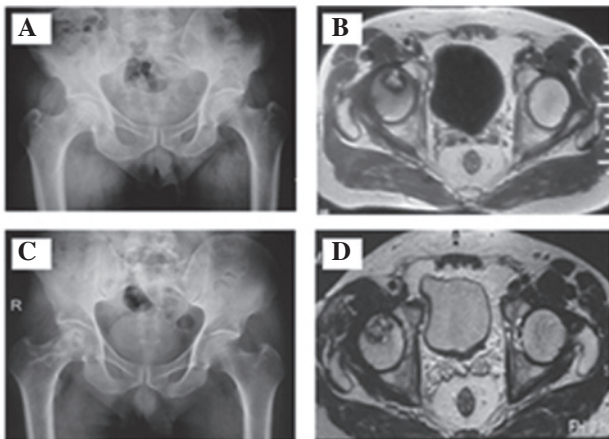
Preoperative (A) X-ray and (B) MRI and postoperative (C) X-ray and (D) MRI at the 1-year follow-up. A 49-year-old man with a 30-year history of heavy drinking (average, 50 ml/day) was admitted to hospital on April 29, 2012 with complaints of right hip pain for more than 3 months and progressive, aggravated claudication. Physical examination revealed limited motion of the right hip joint, a positive Patrick's sign, and feelings of pain under flexion, abduction and extension. The patient was diagnosed with avascular necrosis of the femoral head at ARCO stage IIB. On May 8, 2012, the patient underwent transplantation with iliac bone flaps pedicled with sartorius muscular fascia around the superficial circumflex iliac vessels. MRI, magnetic resonance imaging; ARCO, Association for Research on Osseous Circulation.
